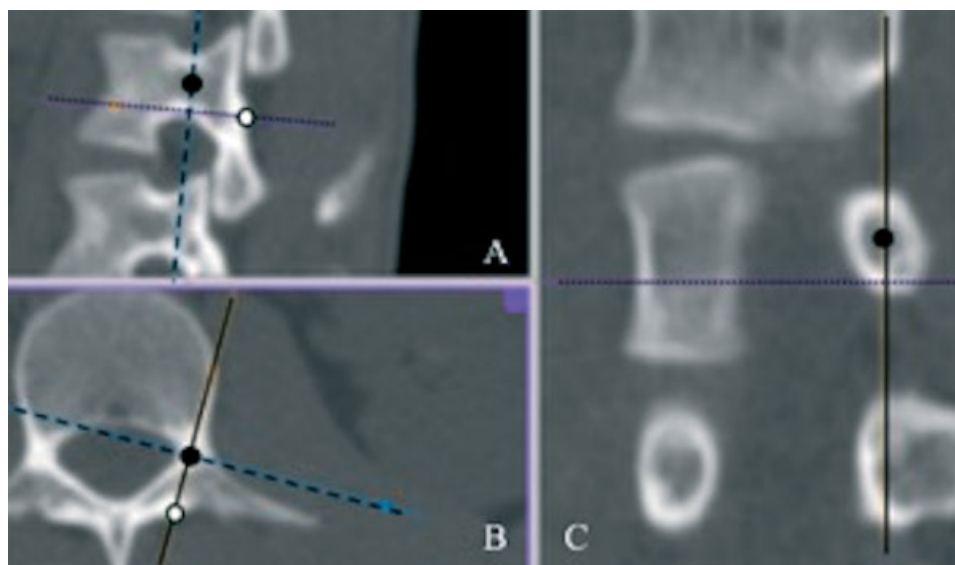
Sagittal (A), axial (B), and coronal (C) computed tomography images showing the lateral trajectory of the screw.
